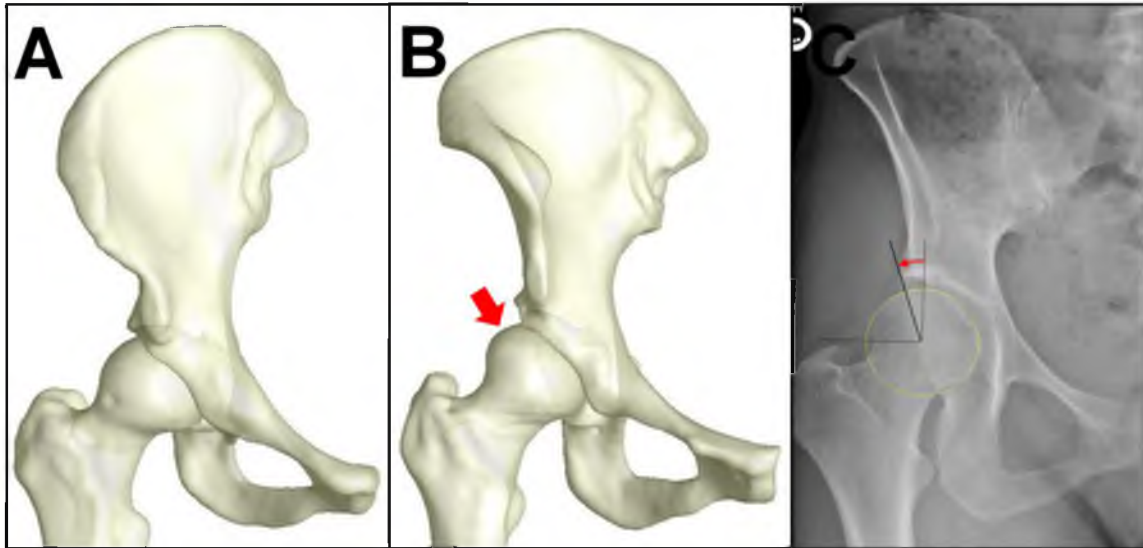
Characteristics of acetabular dysplasia. A – anteroposterior projection of the normal hip. B – anteroposterior projection of the dysplastic hip. The red arrow highlights the undercovered femoral head. C – anteroposterior radiograph of the dysplastic hip showing the center-edge angle. The femoral head is fit to a circle (yellow). The angle between vertical and the lateral edge of the acetabular sourcil is the center edge angle (red).
